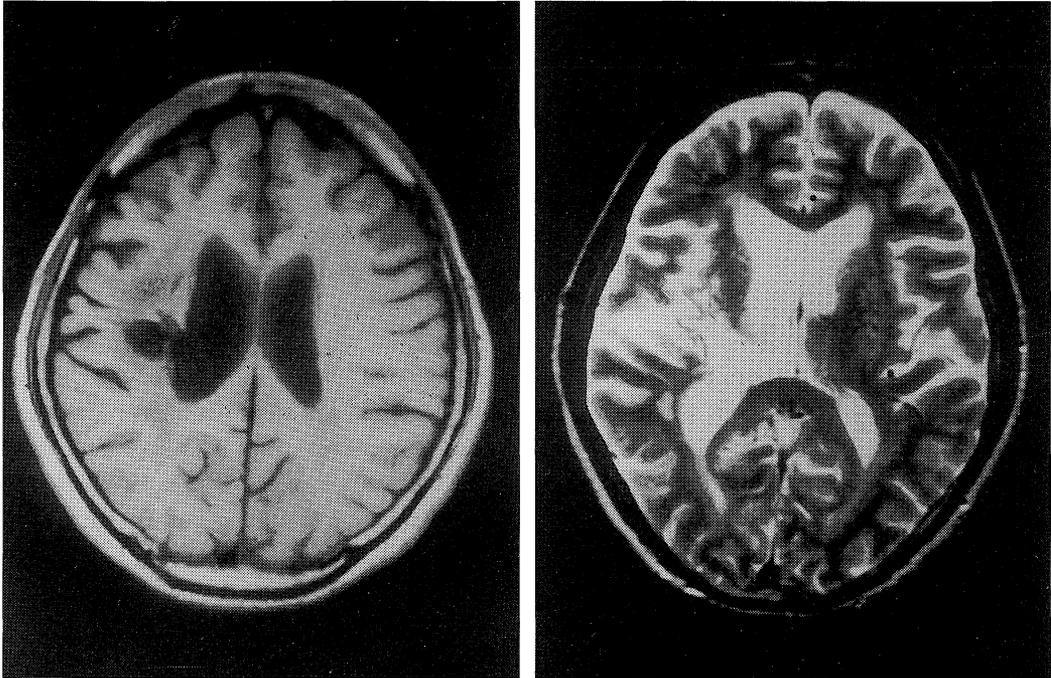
MRI shows spacious lesion (T1 : right, T2 : left) in centrum semioval, corona radiata area, putamen and thalamus in right hemisphere.
